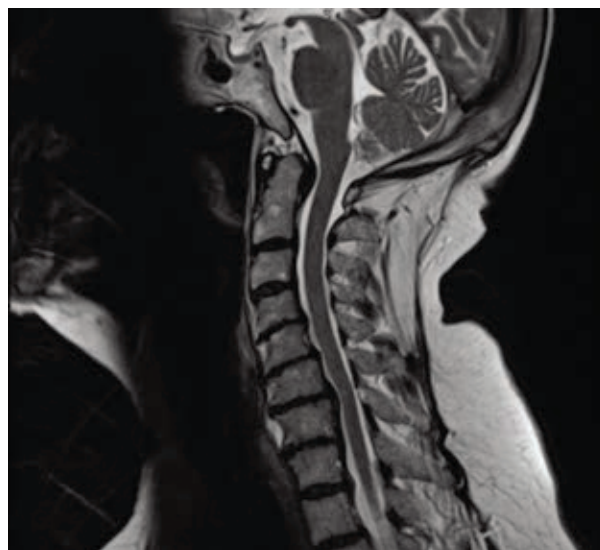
Magnetic resonance imaging of the C-spine was negative for cervical myelopathy.
